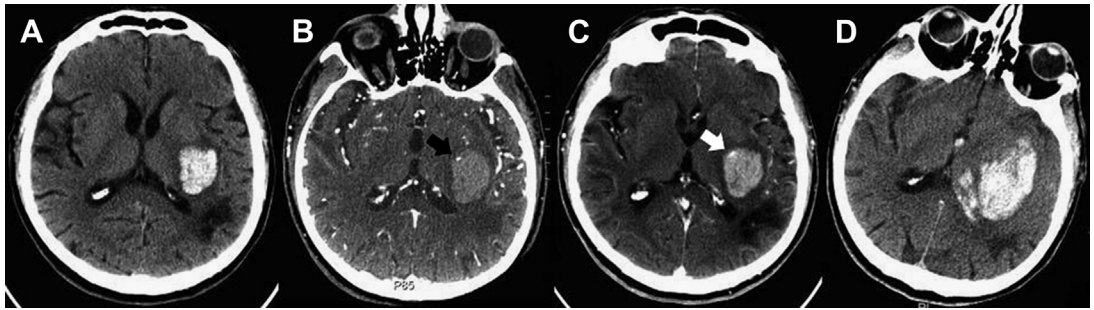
(A) Computed tomographic imaging of a left putaminal hemorrhage. (B, C) CT angiography demonstrating contrast extravasation (spot sign) black arrow in image B and white arrow in image C. (D) Subsequent hematoma expansion detected on CT. (From Wada R, Aviv RI, Fox AJ, et al. CT angiography “spot sign” predicts hematoma expansion in acute intracerebral hemorrhage. *Stroke* 2007;38(4):1257–62; with permission.)
